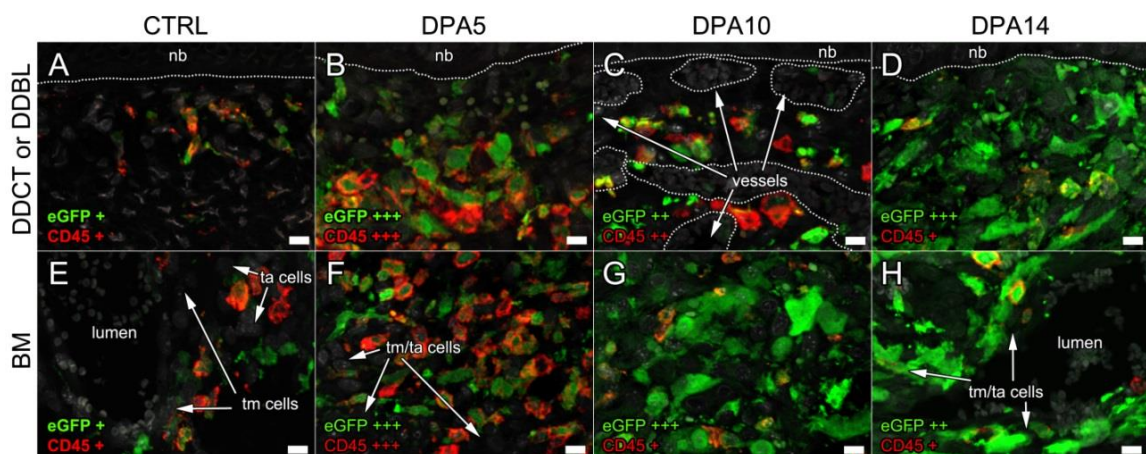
The co-expression of CD45 with eGFP+ BMDCs was dynamically and differentially regulated between digit BM and CT compartments and throughout regeneration timepoints. A shift in the ratio of HPCs to MPCs gated by CD45 expression was observed in the (A-D) dorsodistal connective tissue (DDCT)
